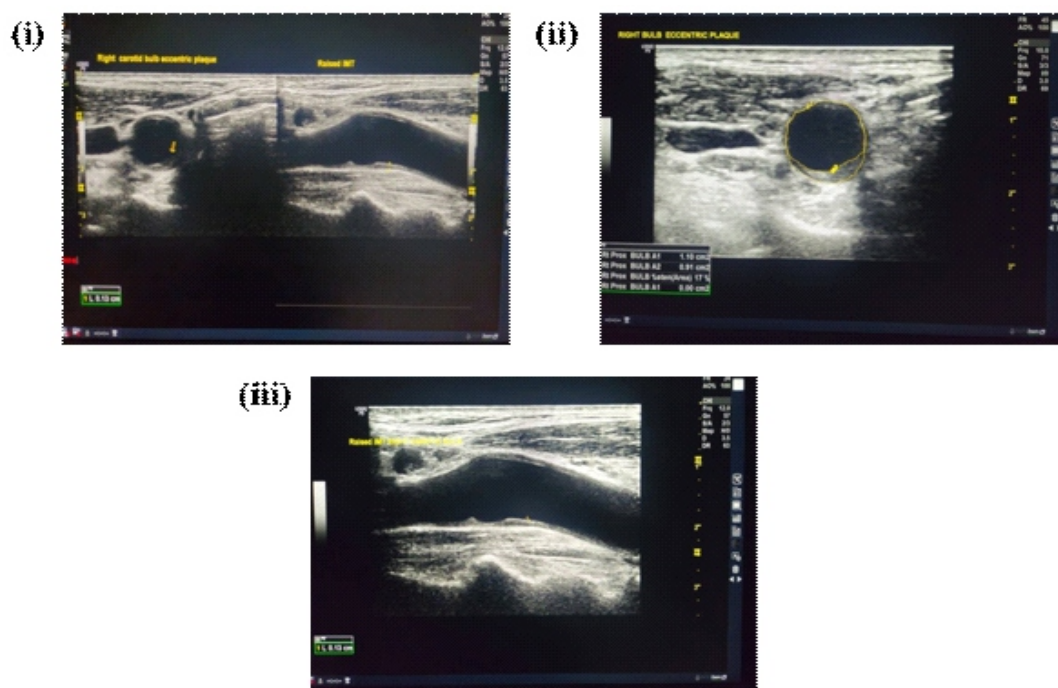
(i) B-mode ultrasound images demonstrating carotid atherosclerotic changes at the right carotid bulb, (ii) Eccentric predominantly echolucent (Grey–Weale type II) atherosclerotic plaque with mild luminal narrowing (~17% area stenosis), (iii) Increased CIMT measuring approximately 1.3 mm.
